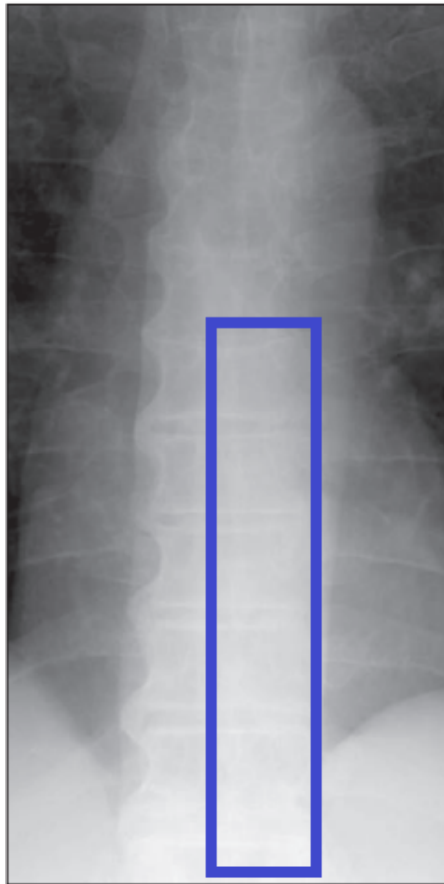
Anterior-posterior x-ray image from 52-year-old man with DISH showing, with the blue rectangle, the location of the four contiguous ossified vertebrae (T7-T11) [Adapted from [36]].
